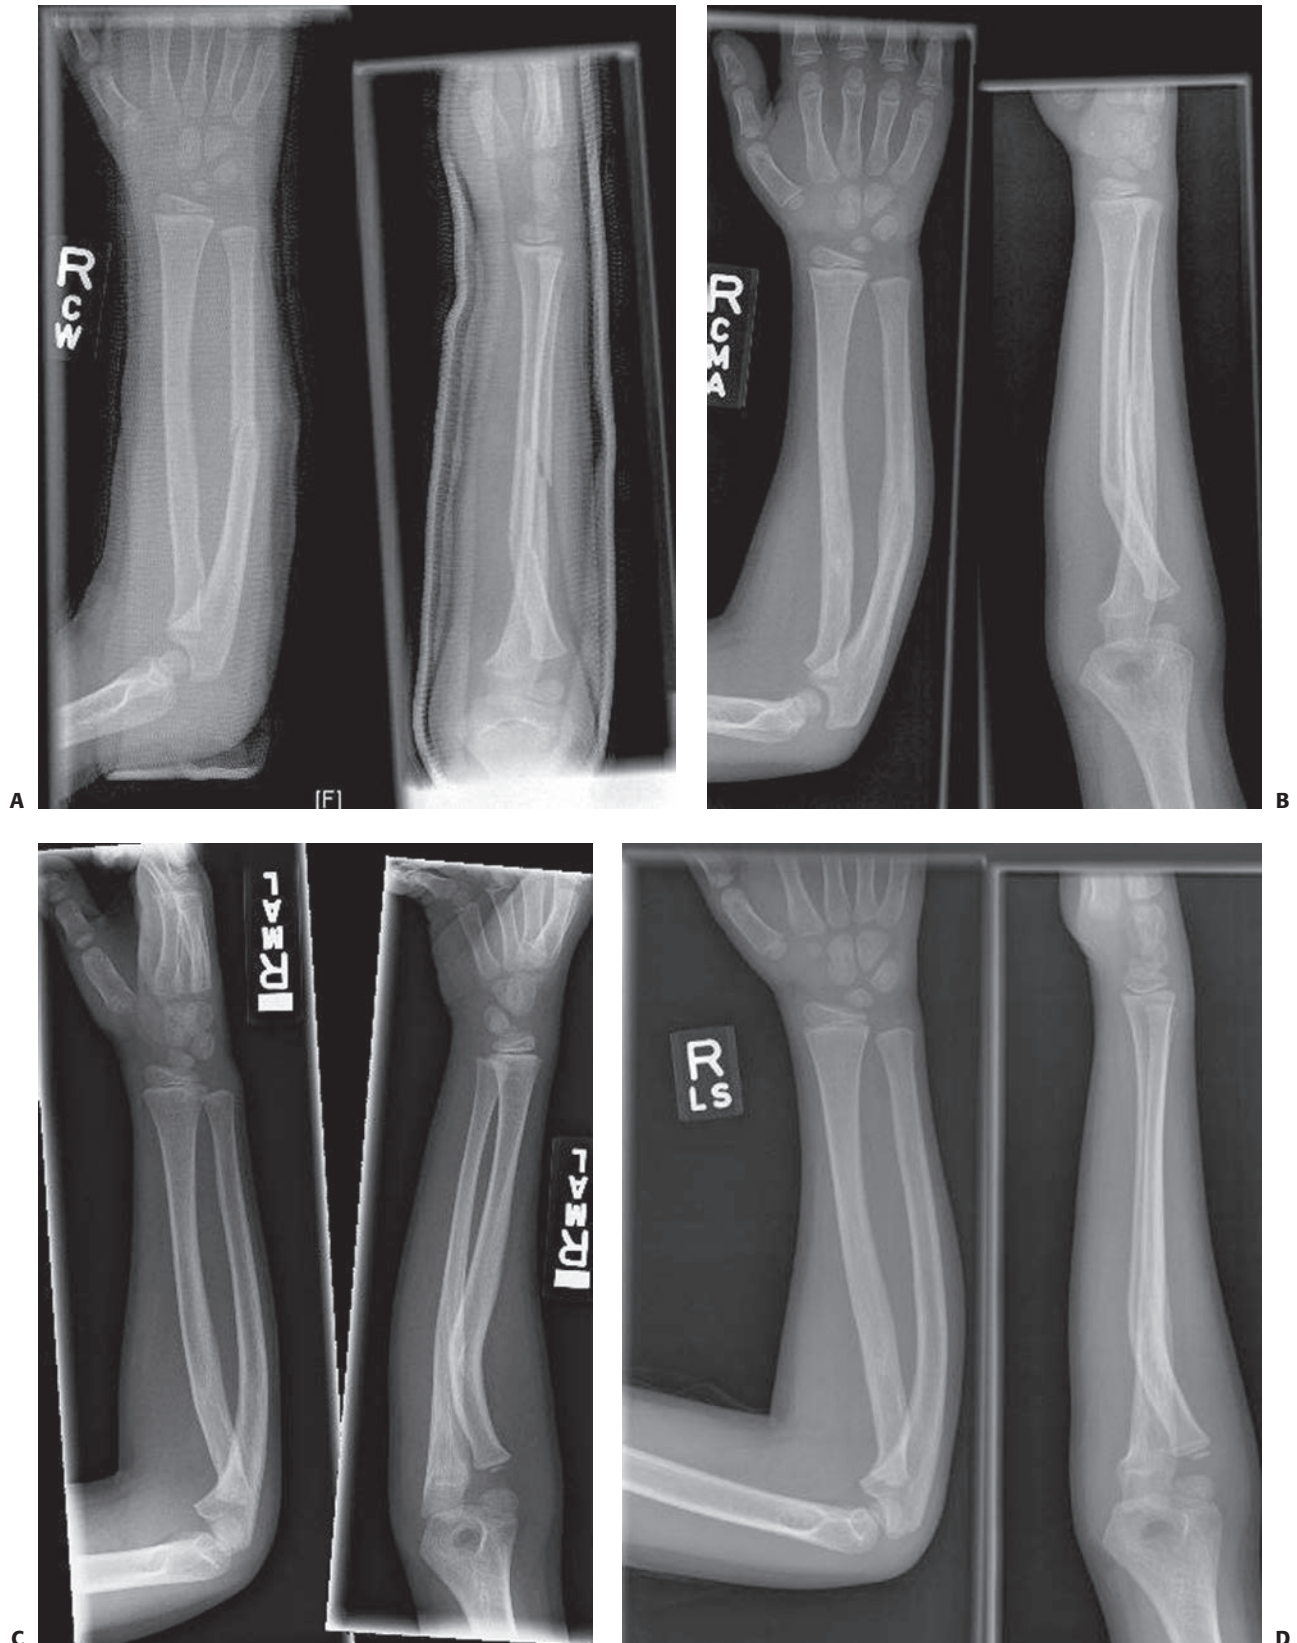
A 6-year-old male who suffered a right forearm shaft malunion. A: Radiograph one week after fracture showing complete midshaft ulnar and proximal-third radial fractures. B: Healed fractures at 6-month follow-up. C: Twenty-month follow-up. D: Twenty-six month follow-up.
